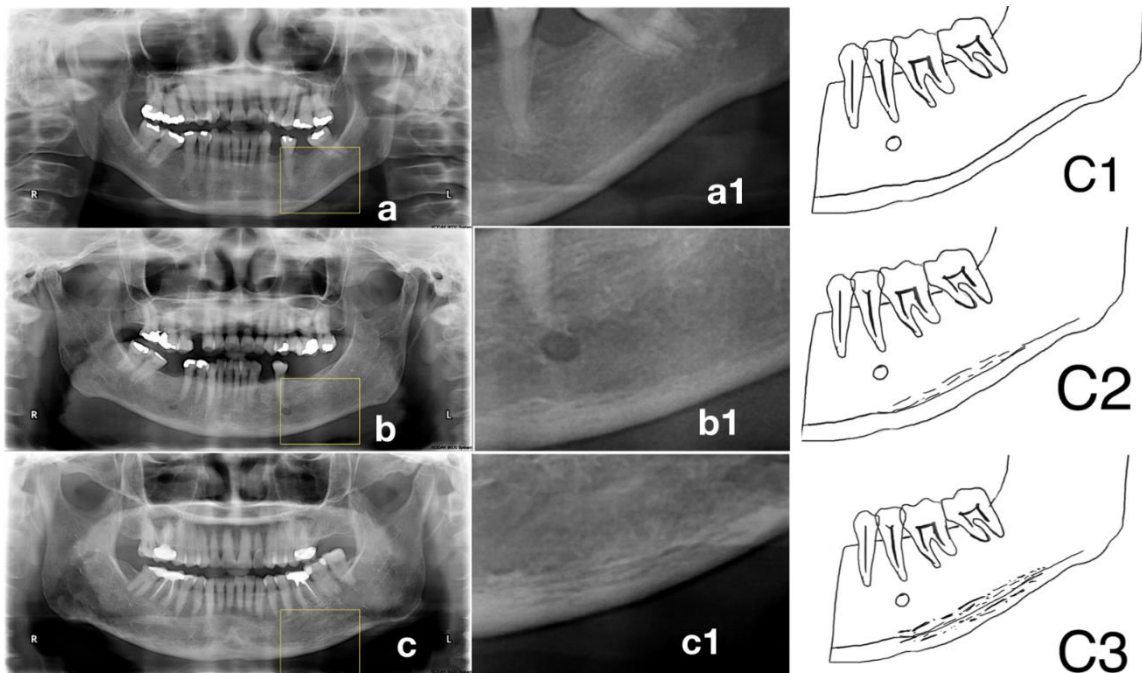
Example of radiographic appearance of mandibular cortical morphology classified by mandibular cortical index (MCI). a, C1: the endosteal margin is even and sharp, a1, magnification of C1 panoramic radiograph. b, C2= the endosteal margin presents lacunar resorption or cortical residues, b1, magnification of C2 panoramic radiograph, c, C3= the cortical layer is clearly porous, with heavy endosteal cortical residues, c1, magnification of C3 panoramic radiograph.
